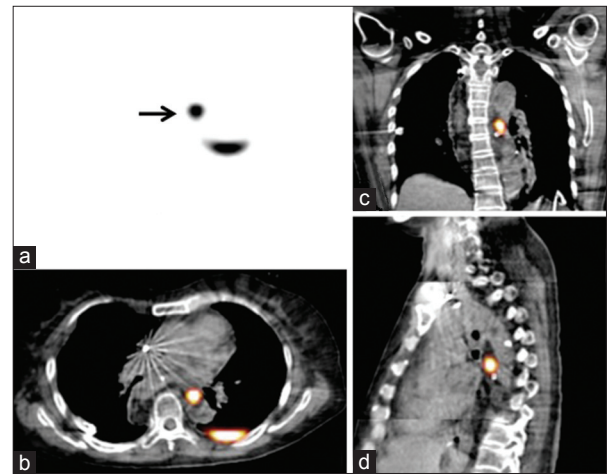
SPECT (a) axial slice, SPECT/CT (b) axial slice, (c) coronal slice and (d) sagittal slice. The SPECT/CT images revealed a hot spot at the level of the tracheal bifurcation, which showed that the hot spot was located at retromediastinum anterior to the descending thoracic aorta and directly above the ligated site of the thoracic duct in comparison with the surgical findings
